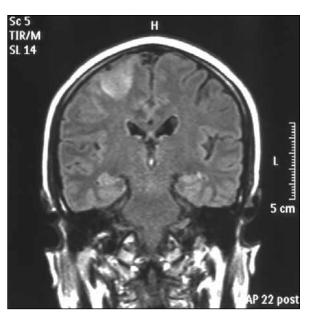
Cranial magnetic resonance imaging sagittal section showing right frontal infarct
